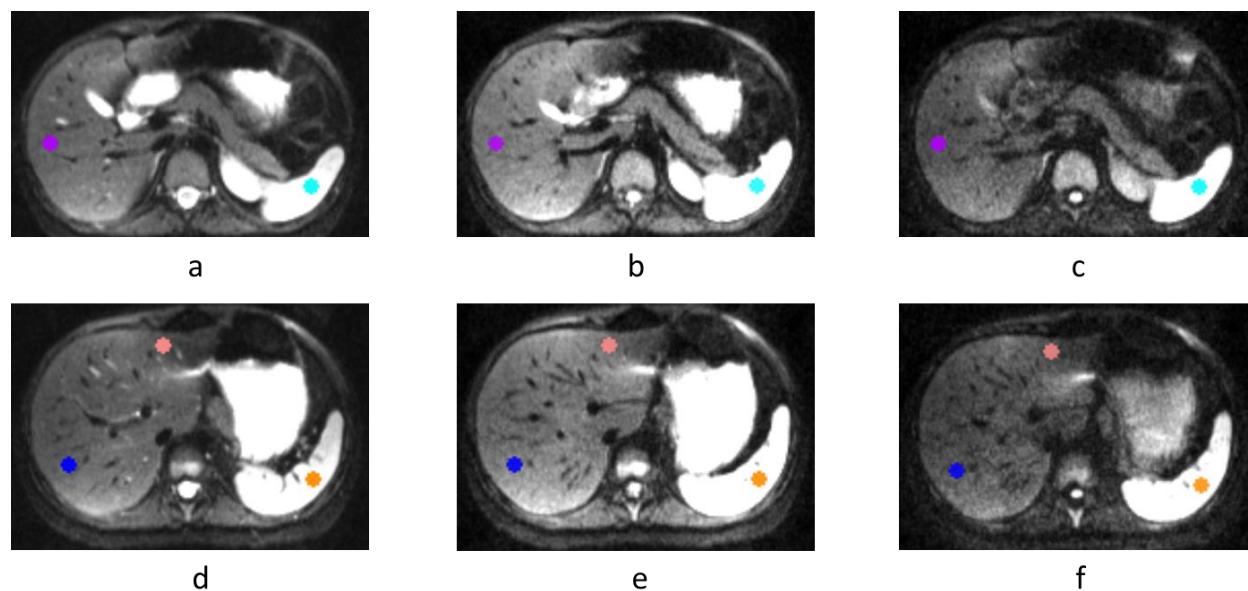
Five ROIs selected in the liver and spleen were overlaid on the DW-MRI with b-values (a, d) 5 s/mm², (b, e) 100 s/mm², and (c, f) 600 s/mm². (a-c) ROI 1 (lower right lobe) in purple and ROI 4 (lower spleen) in cyan and (d-f) ROI 2 (upper right lobe) in blue, ROI 3 (left lobe) in pink, and ROI 5 (upper spleen) in orange.
